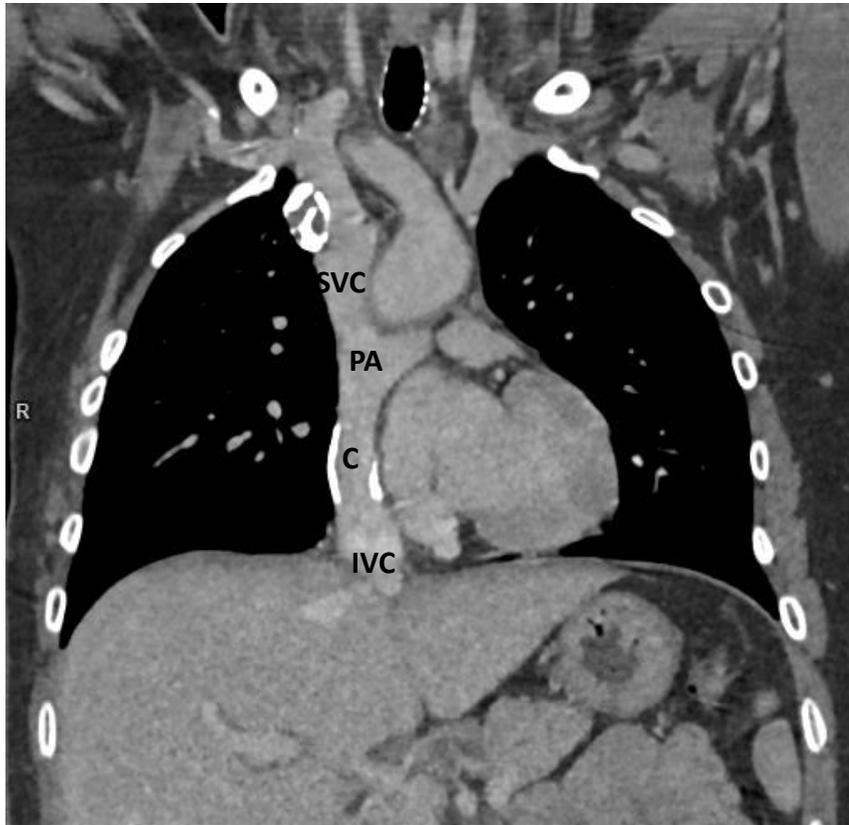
Computed tomography, coronal reformatted image – TCPC extracardiac conduit
